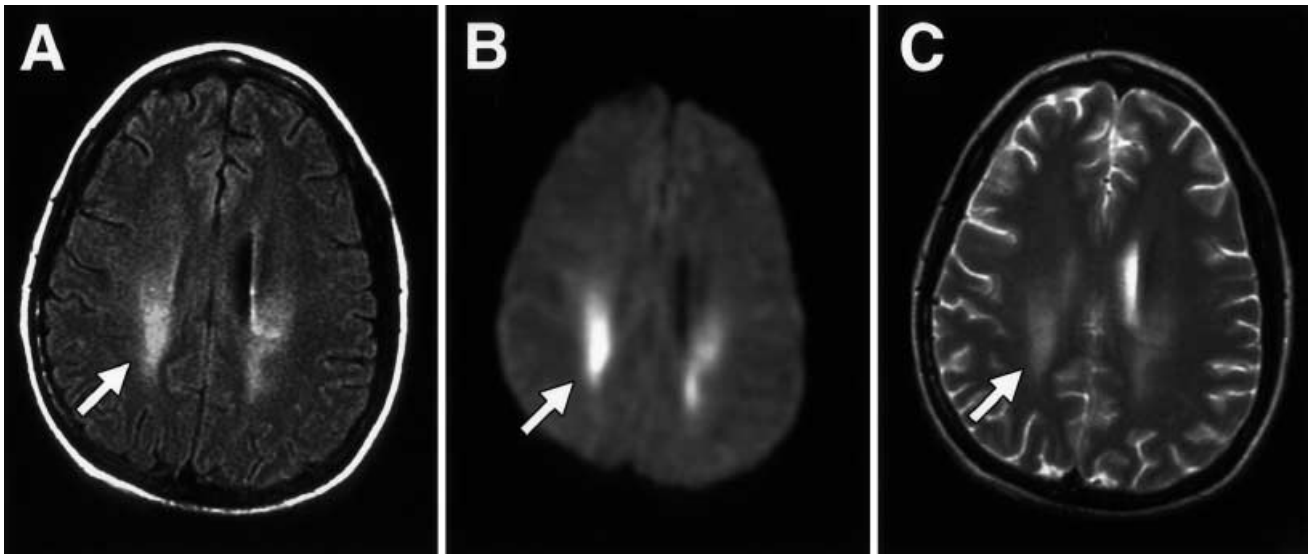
MRI scan of brain showing changes consistent with PML. Long TR (A), diffusion-weighted (B), and T1-weighted post gadolinium (C) magnetic resonance axial images through the brain. Each image is an approximately similar level of the brain, with *arrows* indicating regions of abnormal increased signal intensity in the periventricular white matter of the parietal lobes. No enhancement of the abnormality after administration of contrast (C)
